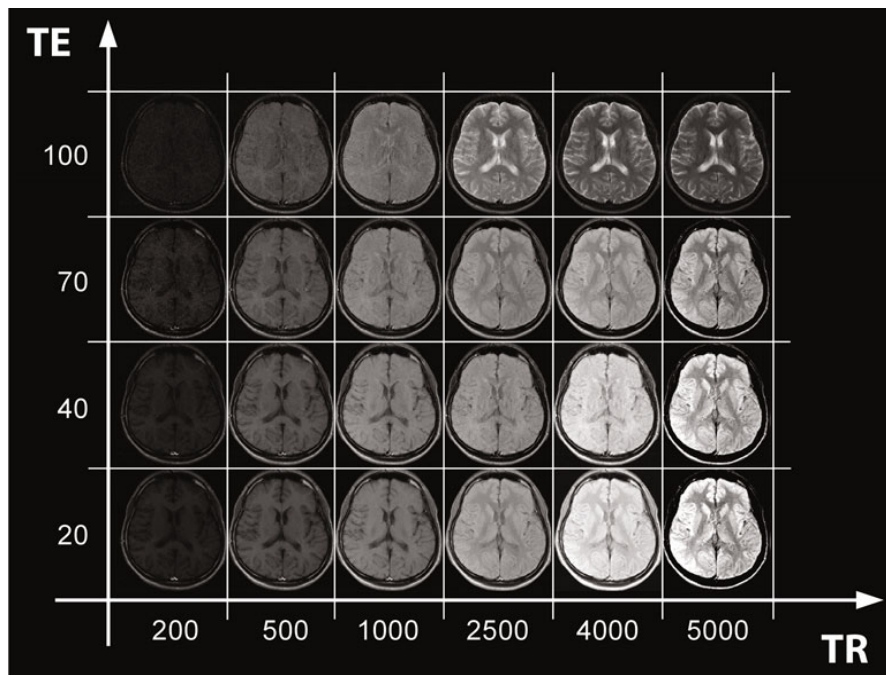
MRI contrast modalities. The Development of the contrasts is related to the change of the extrinsic parameters TR and TE . Low values of TR and TE generate an T_1 -weighted image; high values of TR and low TE , lead to an image depending largely on the proton density of the tissue; high values of both parameters lead to an T_2 -weighted image.
